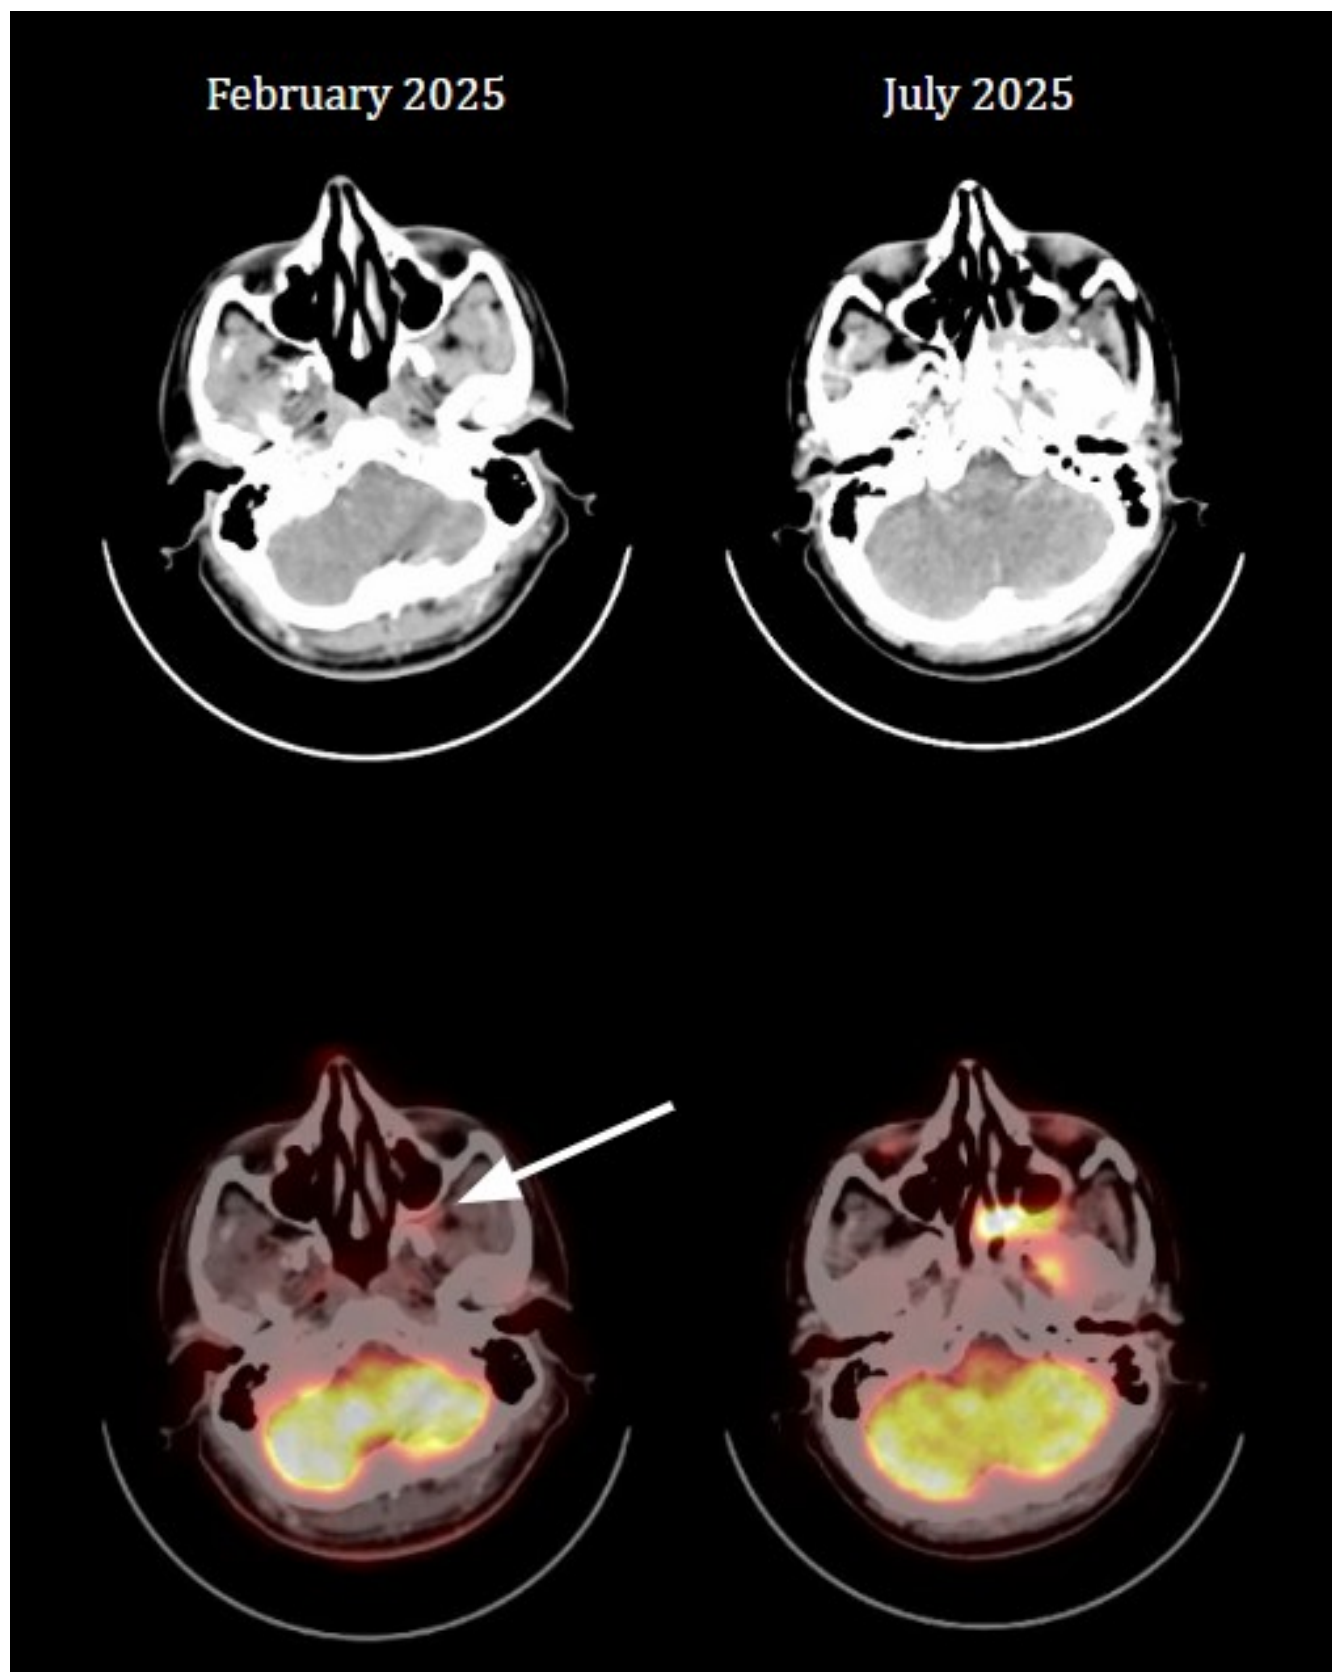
Axial CT and fused PET/CT images corresponding to Figure 1.2 reveal a subtle lesion with abnormal mild FDG uptake in the left pterygopalatine fossa, which was initially missed due to its inconspicuous appearance (arrow).
